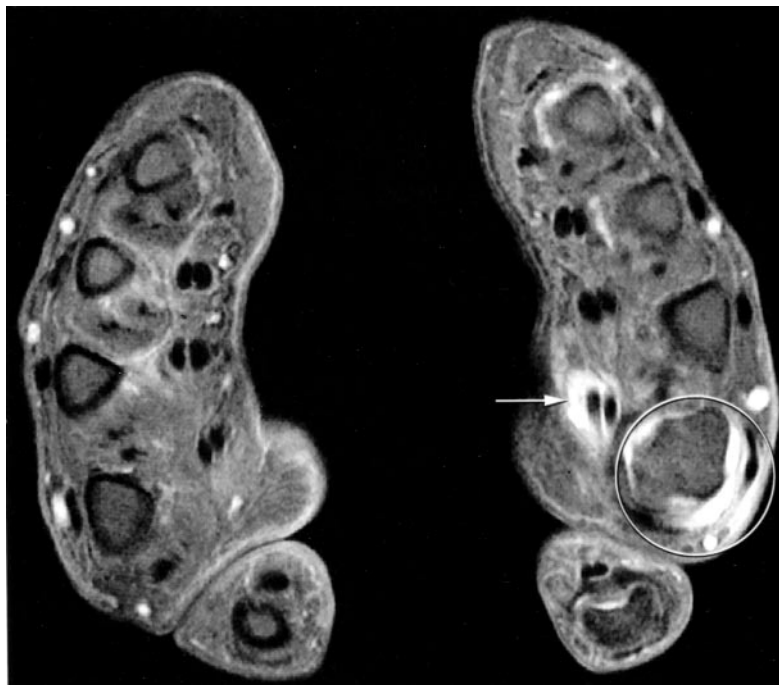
Axial fat suppressed gadolinium enhanced SE T1 weighted MR image in a 53-year-old woman with early RA shows unilateral synovitis in the 2nd left MCP joint (circle). Note also the presence of flexor digitorum synovitis (arrow).
